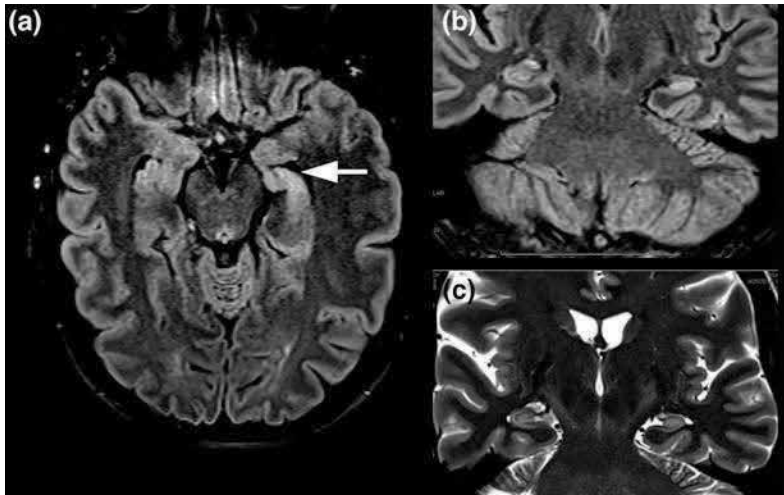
Axial FLAIR (a) demonstrates enlargement of the left lateral ventricle temporal horn and the left hippocampus is relatively smaller and hyperintense compared to the contralateral side. Note that the lateral aspect of the hippocampal body is abnormally smooth, and hippocampal head digitations are reduced (*arrow*). Companion coronal FLAIR (b) and T2-weighted MRI (c) demonstrate volume loss, hyperintensity, and subtle laminar blurring. These are classic MRI findings for left hippocampal sclerosis. If the amygdala also is involved, this can be classified as left mesial temporal sclerosis.
